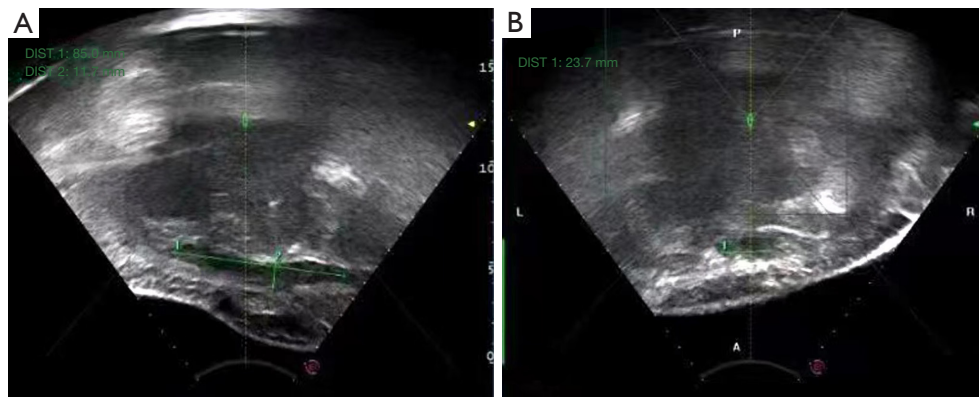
Two-dimensional ultrasonography showing that the rectus abdominis endometriosis was hypoechoic, with ill-defined borders. (A) Longitudinal section. (B) Transverse section.
